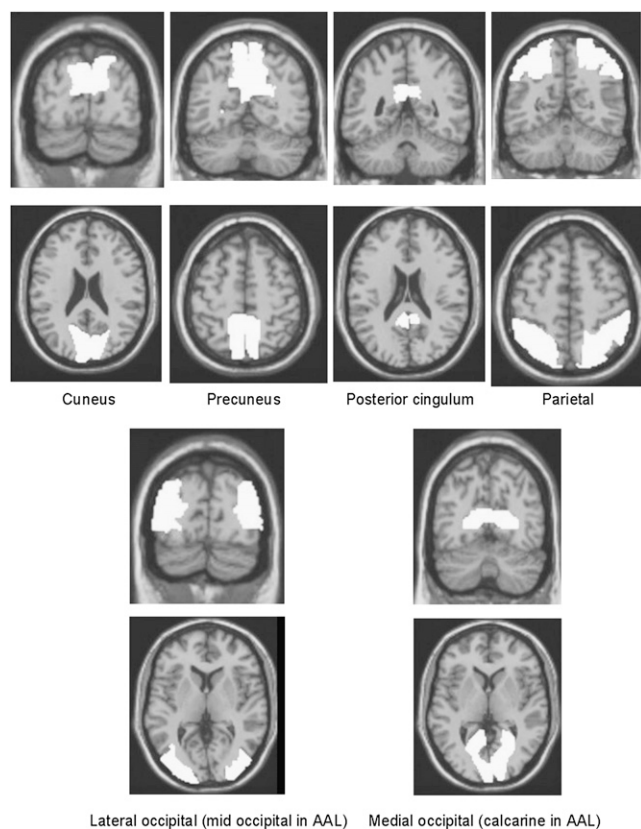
Axial and coronal images of ROIs as identified via AAL template for ^{18}F -FDG PET scans. Regions shown were normalized to cerebellar cortex and compared in DLB and AD cohorts.
